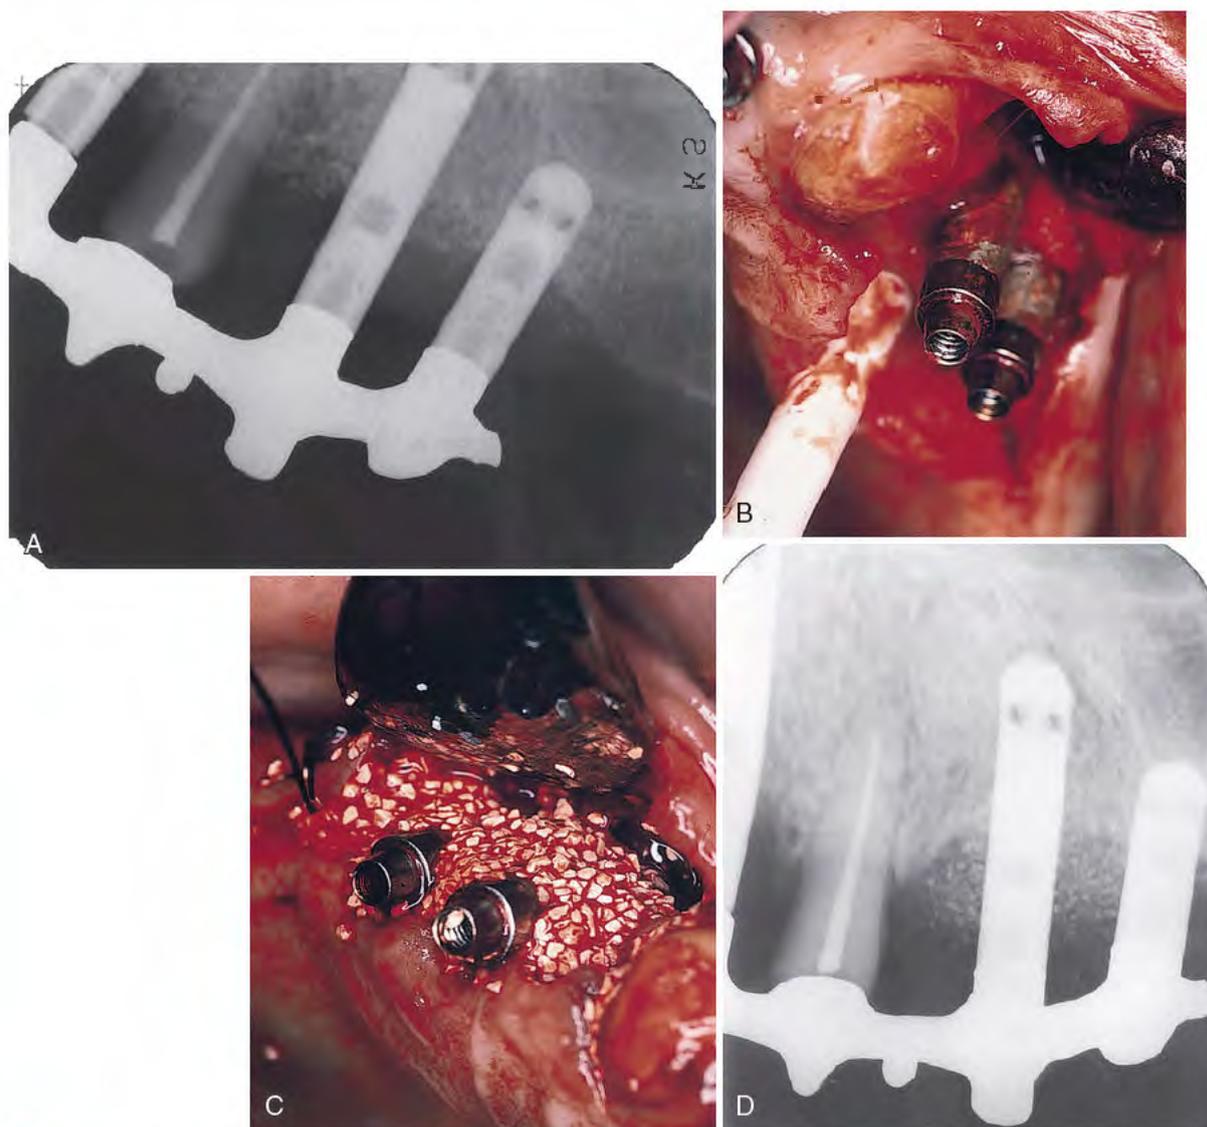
A, This radiograph shows significant bone loss around Integral implants coated with hydroxyapatite (HA). B, A generous, well-vascularized flap is elevated as an introduction to treatment. The HA coating is removed with an ultrasonic tip. If no sign of active infection is seen, citric acid treatment can be used. C, Particulate HA in an autogenous blood slurry is used as a graft material. D, A postoperative radiograph shows an improved environment.
